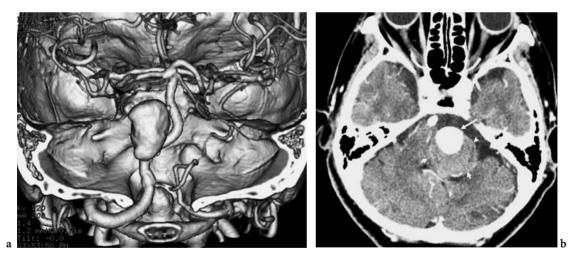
A 67-year-old woman with an unruptured giant aneurysm of the left vertebral artery. a Volume-rendered CTA from behind and above shows a giant aneurysm of the left vertebral artery. Thrombus in the aneurysm is not depicted. b Axial source image of CTA shows partial thrombus (*arrowheads*) within the aneurysm. The lumen of the aneurysm is located anteriorly (*arrow*).
